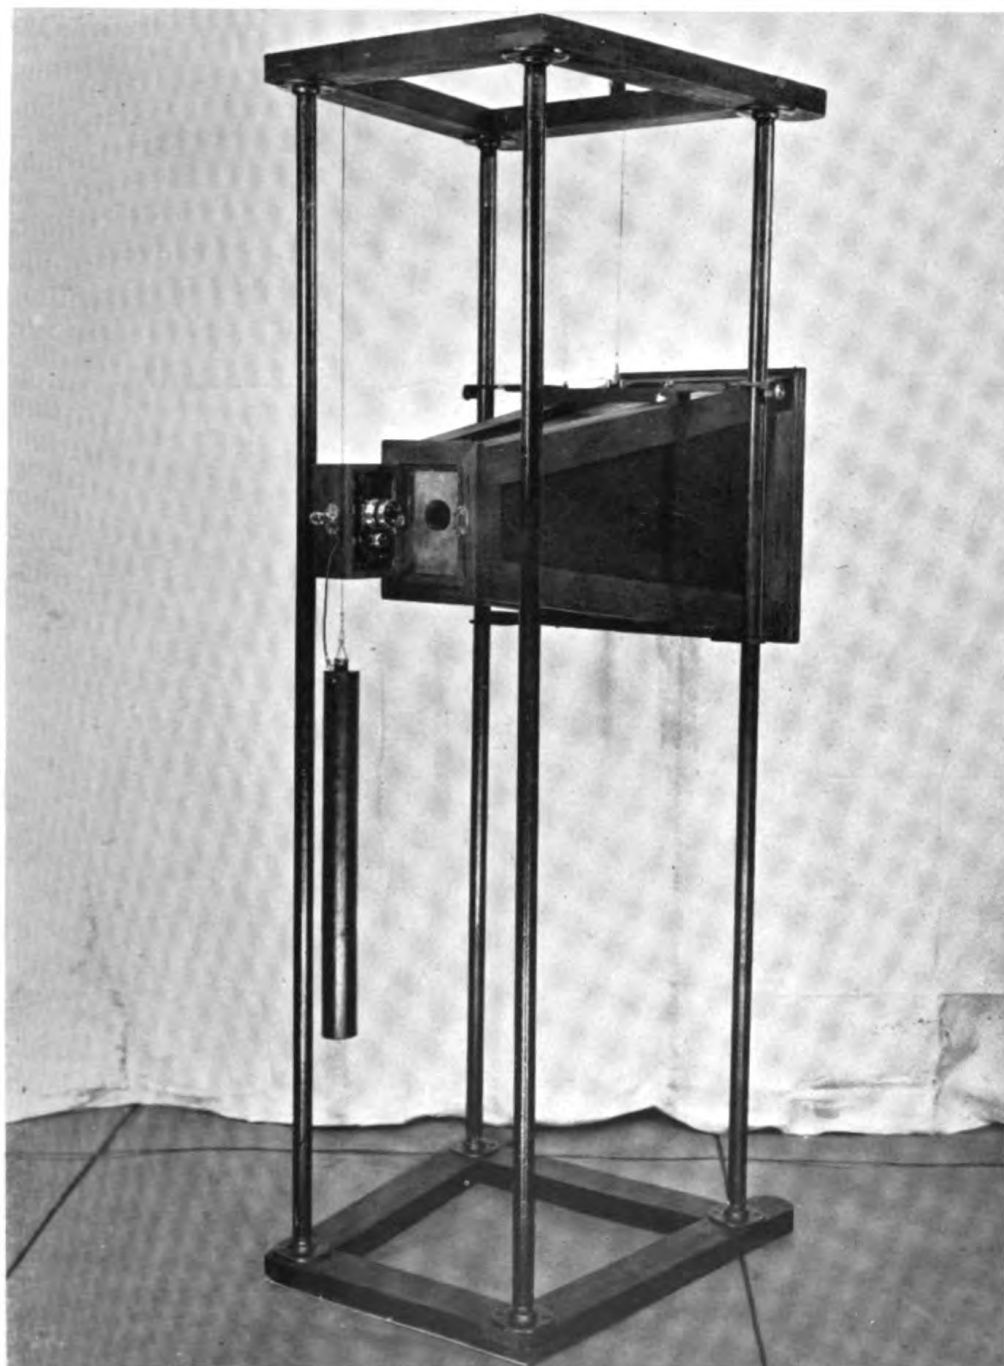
ROENTGEN PHOTOGRAPH UNIT
